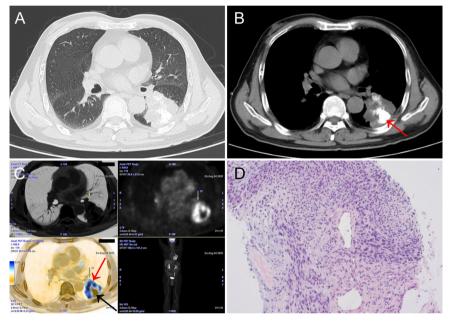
(A, B) Chest CT: An irregular mass is seen in the lower lobe of the left lung, measuring 57 mm × 54 mm, with central patchy calcification (red arrow). (C) Axial PET-CT fusion image: A hypermetabolic mass in the lower lobe of the left lung with an SUVmax of 5.8. The high metabolic area corresponds to the soft tissue component (red arrow), while the calcified area shows no metabolism (black arrow). (D) Pathological result: Malignant peripheral nerve sheath tumor with calcification.
